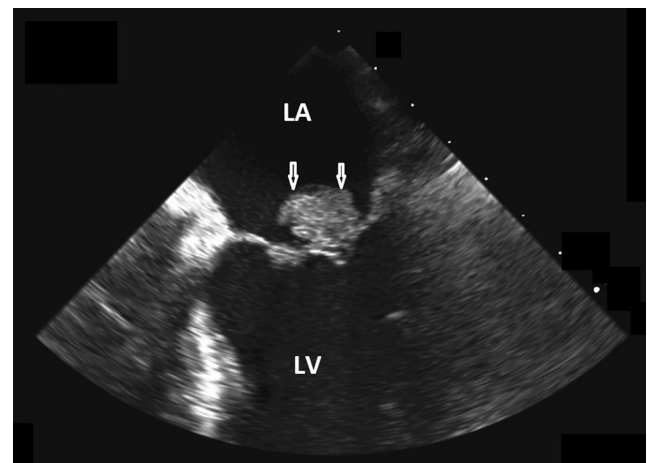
This is a 50-year-old woman with anti-phospholipid antibody syndrome presenting with a stroke. Transoesophageal echocardiogram shows a large mobile mass on the mitral valve (*arrows*). *LA* left atrium, *LV* left ventricle
